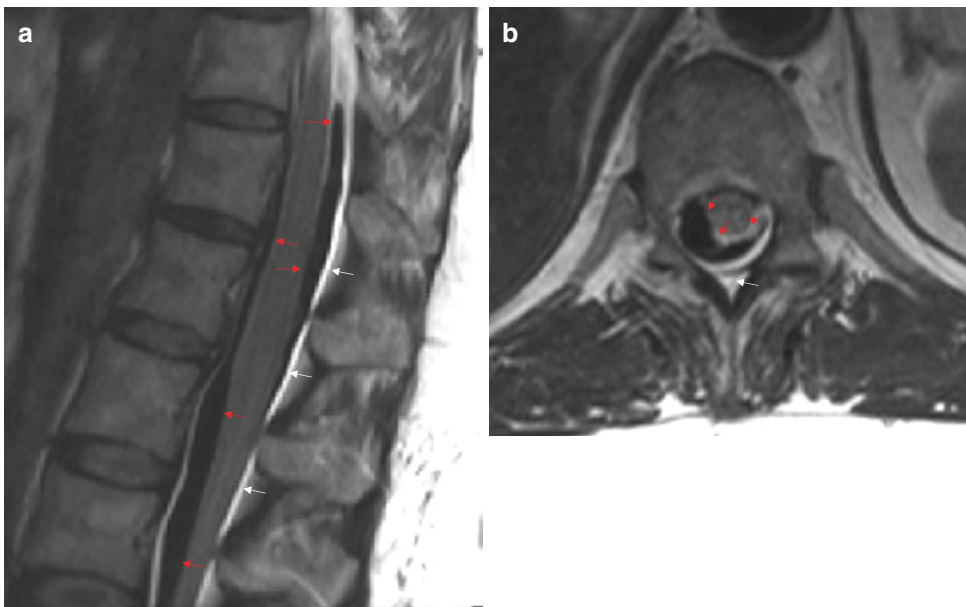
(a) Sagittal and (b) axial T2-weighted images demonstrate T2 hypointense fluid in the subdural space compatible with subdural hematoma (red arrows). Note
